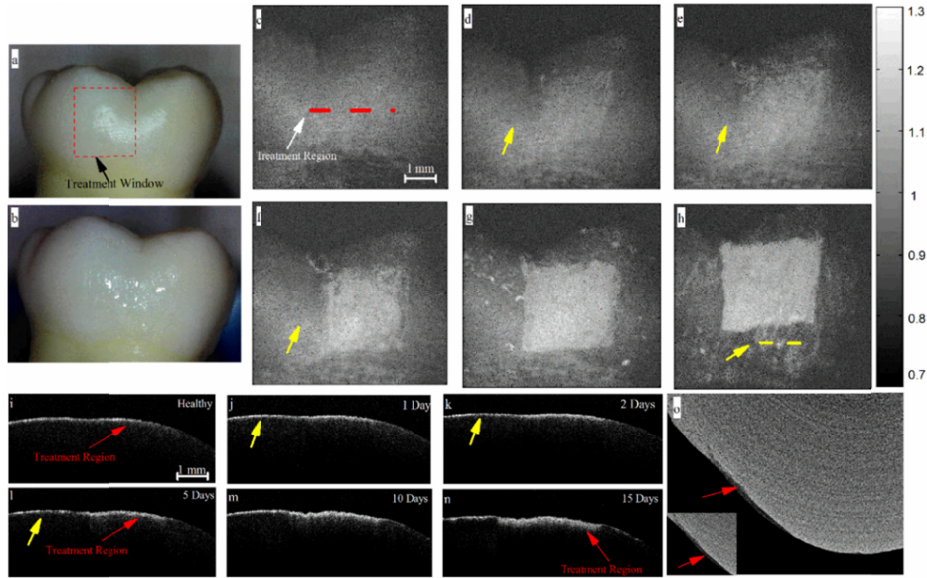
Optical image of the smooth surface of extracted human molar (a) before demineralization and (b) after 15 days of demineralization on the treatment window. Integrated en-face OCT images at (c) 0 days, (d) 1 day, (e) 2 days, (f) 5 days, (g) 10 days, and (h) 15 days of demineralization. B-scan OCT images at (i) 0 days, (j) 1 day, (k) 2 days, (l) 5 days, (m) 10 days, and (n) 15 days of demineralization. (o)  $\mu$ CT image of 15-day treated sample.
